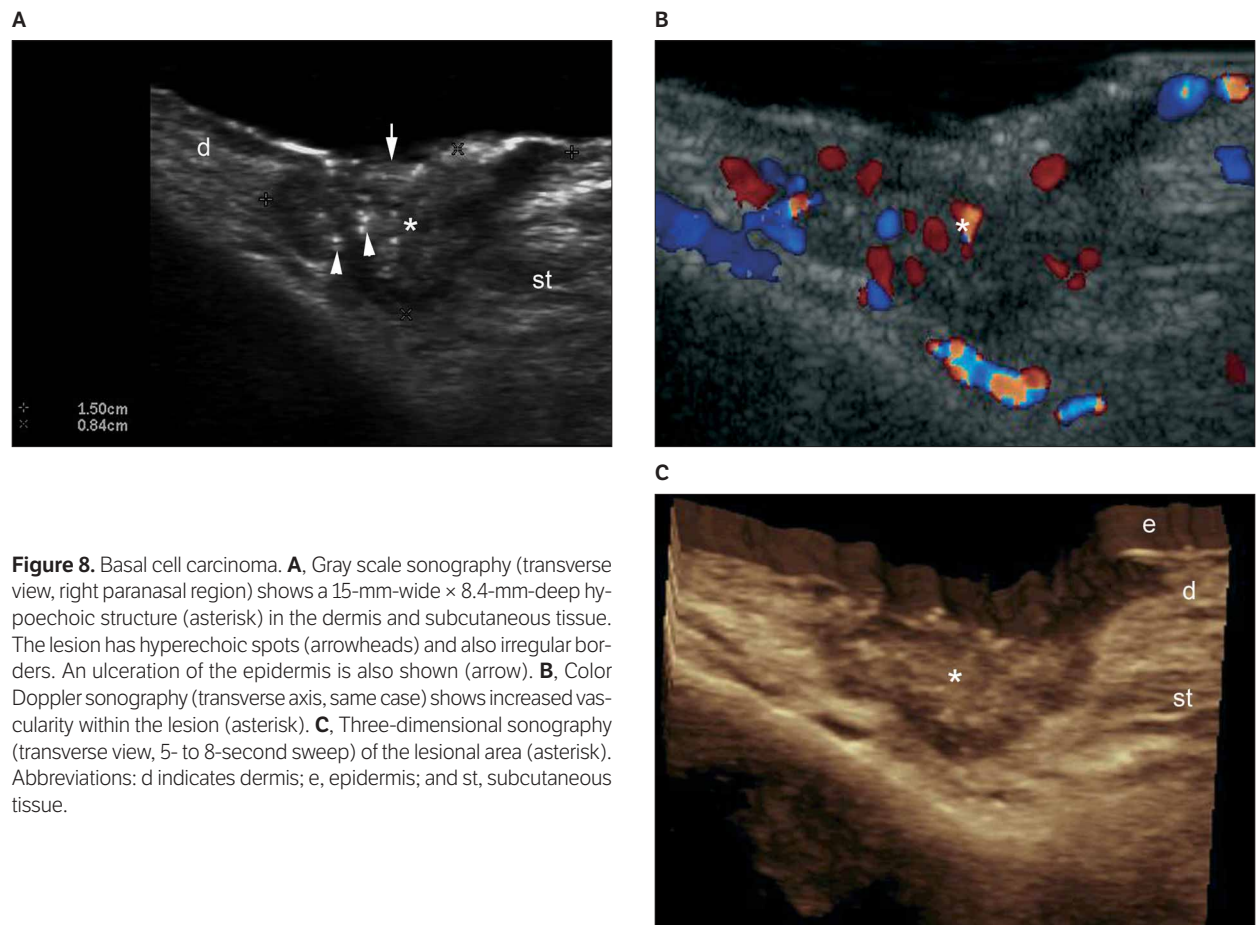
Basal cell carcinoma. A. Gray scale sonography (transverse view, right paranasal region) shows a 15-mm-wide × 8.4-mm-deep hypoechoic structure (asterisk) in the dermis and subcutaneous tissue. The lesion has hyperechoic spots (arrowheads) and also irregular borders. An ulceration of the epidermis is also shown (arrow). B. Color Doppler sonography (transverse axis, same case) shows increased vascularity within the lesion (asterisk). C. Three-dimensional sonography (transverse view, 5- to 8-second sweep) of the lesional area (asterisk). Abbreviations: d indicates dermis; e, epidermis; and st, subcutaneous tissue.
